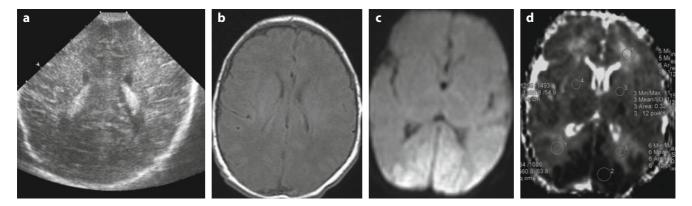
Neuroimaging performed 2 h after the onset of a severe hypoglycaemic event: coronal CUS (a) and MR axial T1 (b) scans showed no abnormality, which was different to MR axial DWI (c) and the axial ADC map (d), which showed respectively reduction and pathologically low ADC values in the posterior areas of the brain
